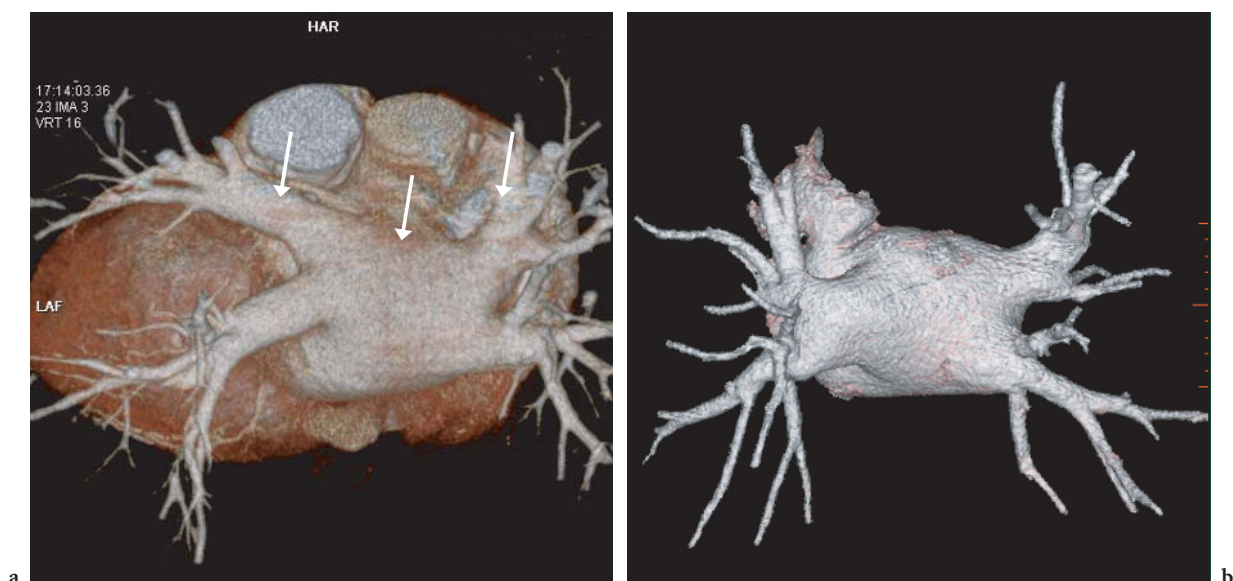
Patient examined with 16-slice CT to visualize the pulmonary vein for planning of an ablation procedure. Special contrast agent protocols are required for imaging the cardiac venous system. High-quality image data of the pulmonary vein, including side branches (a, arrows) can be provided as input for special segmentation software (b). (Case courtesy of Massachusetts General Hospital, Boston, USA)
